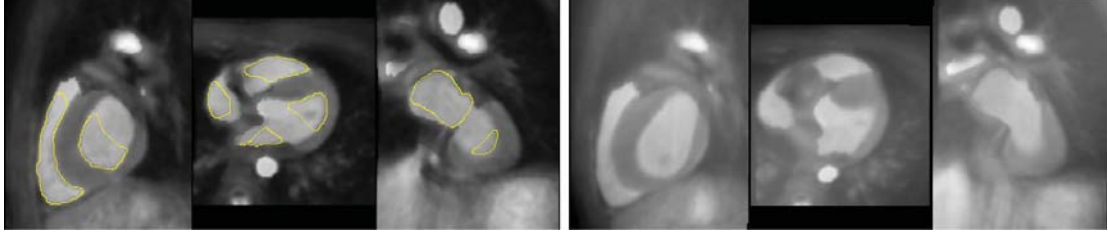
The cardiac MR images for registration. Left: The MR image superimposed on by the contour of four pre-defined local regions. Right: The MR image with a 100% bias field and deformed by an initial transformation with warping index of 7.54 mm.
